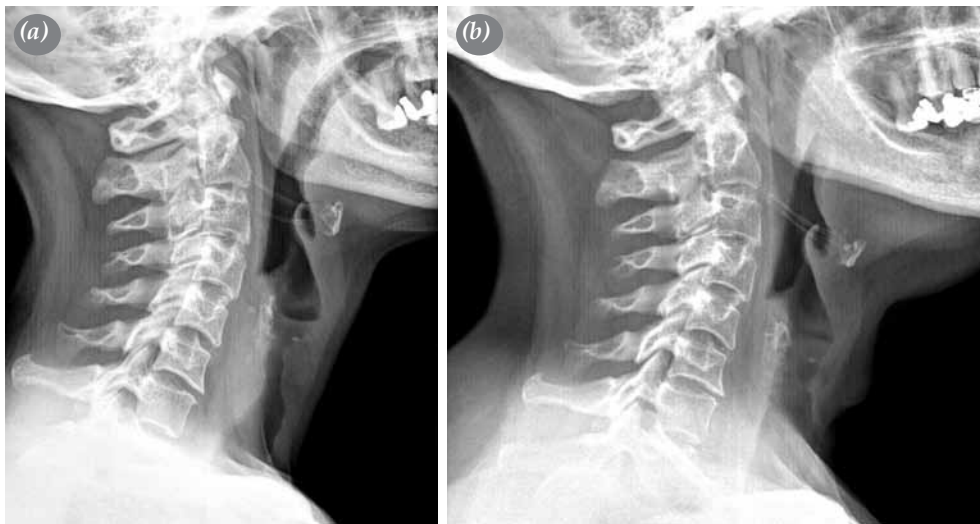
(a) A preoperative lateral cervical radiographic view of the area of subglottic stenosis and (b) a postoperative lateral cervical radiographic view of the patent subglottic area 12 months after the removal of the T-tube.
